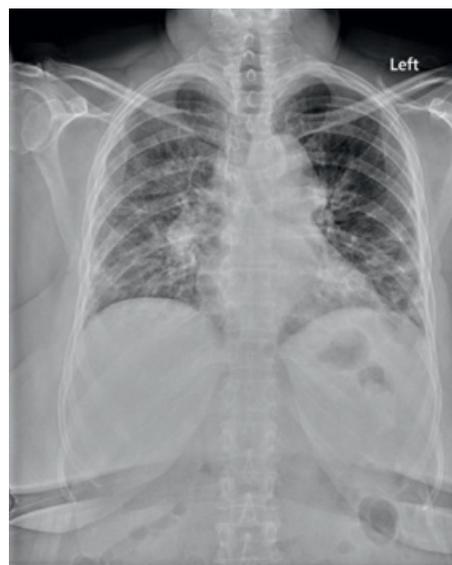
Chest x-ray with left lower lobe and middle lobe.
